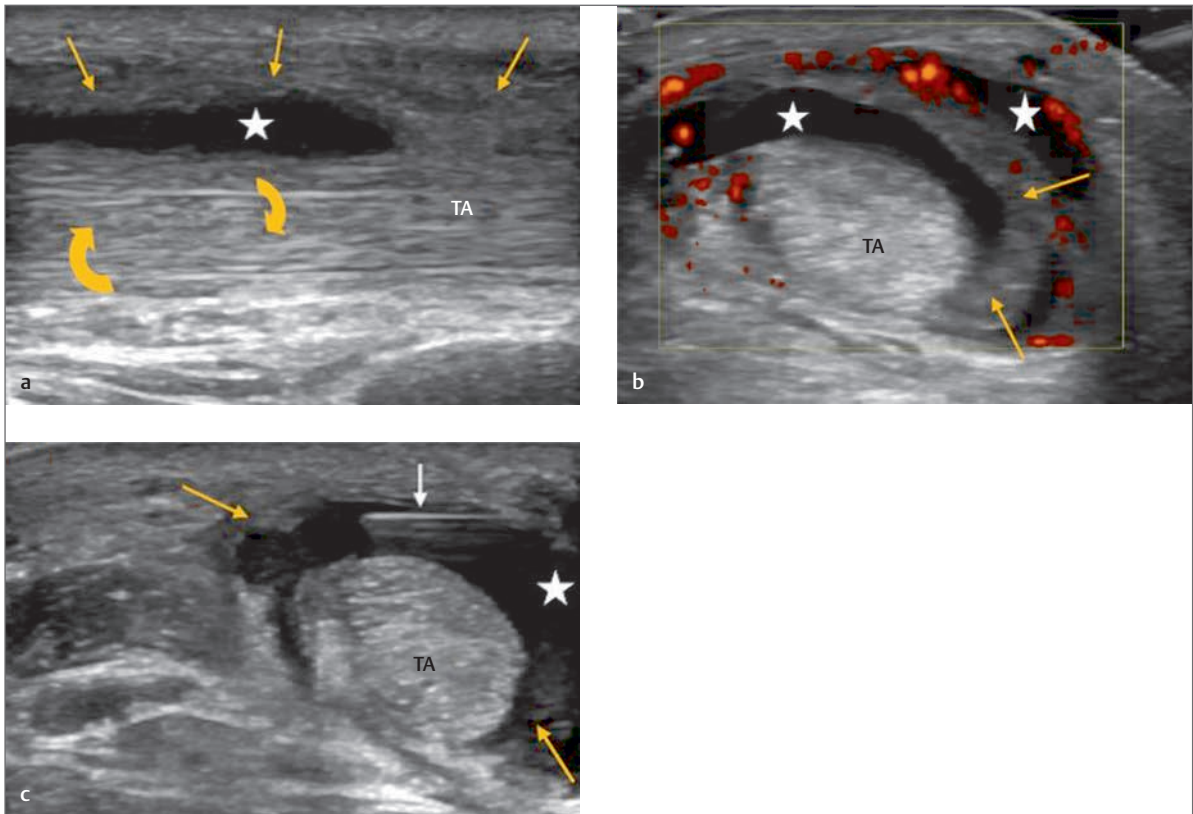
(a) Longitudinal image of the tendon of tibialis anterior (TA) over the anterior aspect of the ankle joint. The tendon is of good fibrillar pattern and appears echogenic other than a longitudinal intrasubstance region (*curved arrow*) suggestive of a possible intrasubstance tear. There is, however, both an effusion (*white star*) and synovial thickening (*yellow arrows*) within the tendon sheath in keeping with a tenosynovitis. (b) Transverse image of the tendon of tibialis anterior (TA) demonstrated in part (a). The tendon in this image appears intact with no evidence of intrasubstance pathology. There is, however, significant effusion around the tendon (*white star*) and synovial thickening (*yellow arrows*). In addition, in this image Power Doppler demonstrates an active synovitis in keeping with tenosynovitis. (c) Transverse image of the tendon of tibialis anterior (TA) as demonstrated in parts (a) and (b). In this image a needle has been introduced into the tendon sheath in short axis (*white arrow*) prior to injection of corticosteroid into the sheath. Curved arrow, loss of normal intrasubstance fibrillar pattern; white arrow, needle; white star, fluid within tendon sheath; yellow arrows, synovial thickening.
